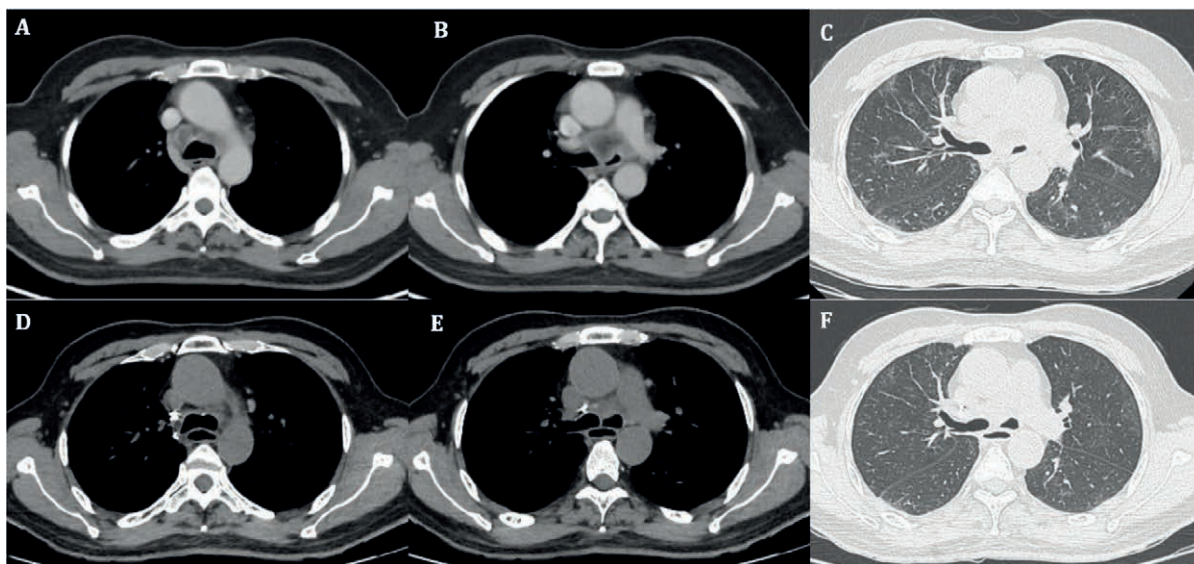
CT thorax (A-C) at the time of diagnosis; A,B) necrotic mediastinal lymph node enlargement in the paratracheal and pre-carinal region with compression of the left main bronchus; C) ground glass opacities in the peripheral subpleural location. CT thorax (D-F) after 6 weeks of therapy, showing near complete resolution of the lymph node enlargement and the ground glass opacities.
